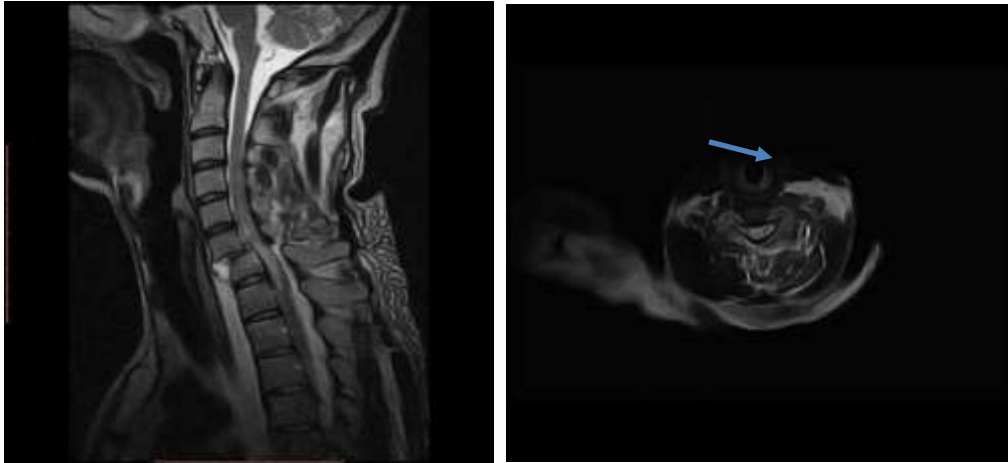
T2WI Sagittal and Axial cervical spine MRI of a 32-year old male involved in a motor vehicle accident. The images show traumatic spondylolisthesis C6 over C7 with associated transection of the spinal cord, cord oedema and resultant compression of the spinal cord.
